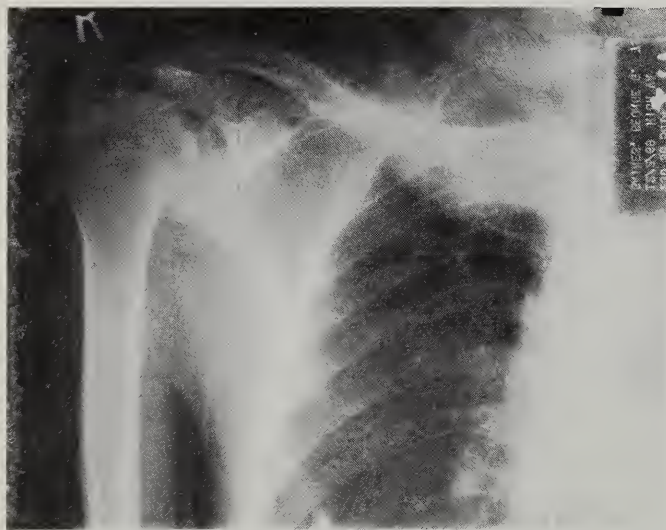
X-ray showing absence of posterior portions of right 2nd and 7th ribs.
